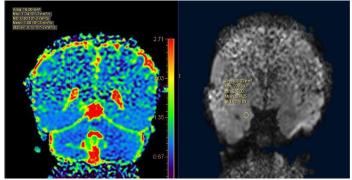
ADC image of posterior section of Figure 7: Diffusion MR image of right right hippocampus anygdala
